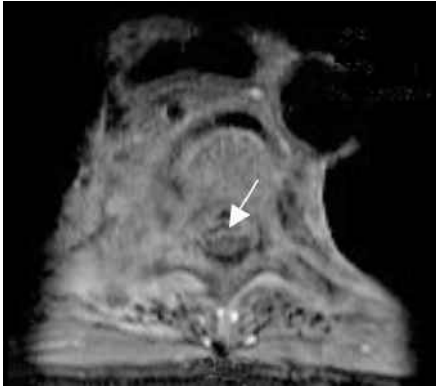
Contrast-enhanced axial T1-W MR image of the T5 vertebra shows the vertebral body, right pedicular and transverse process infective changes and anterior epidural abscess (arrow).
